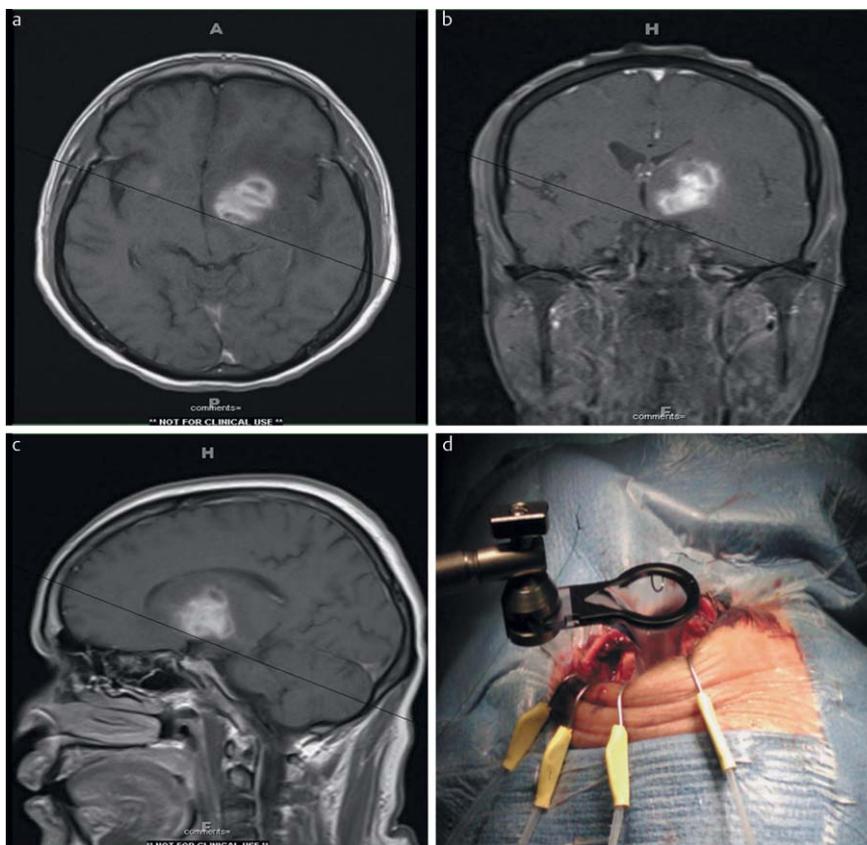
Pre-operative T₁-weighted contrast enhanced MRI with axial (a), coronal (b) and sagittal (c) slices demonstrating contrast enhancing lesion with the left caudate head. An excisional biopsy was performed as a left supraorbital craniotomy via eyebrow incision (d).
